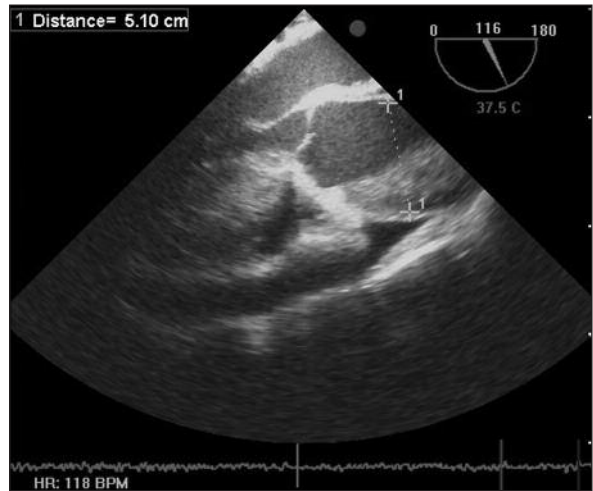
Transoesophageal echocardiographic view of ascending aorta with a thrombus in the lumen.
